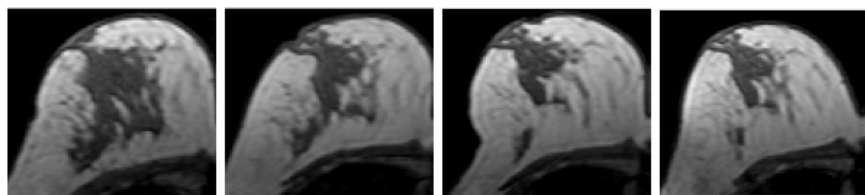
A 41 y/o woman with invasive ductal cancer in the left breast. Four images selected from the normal right breast taken at 4 time points (baseline, F/U-1, F/U-2, F/U-3) are shown. The density reduction in all follow-up MRI can be noted visually. The percentage reduction compared to the baseline density is 31% at F/U-1 after 2 AC, 35% at F/U-2 after 2 AC + 1 taxane, and 39% at F/U-3 after completing the NAC treatment.
